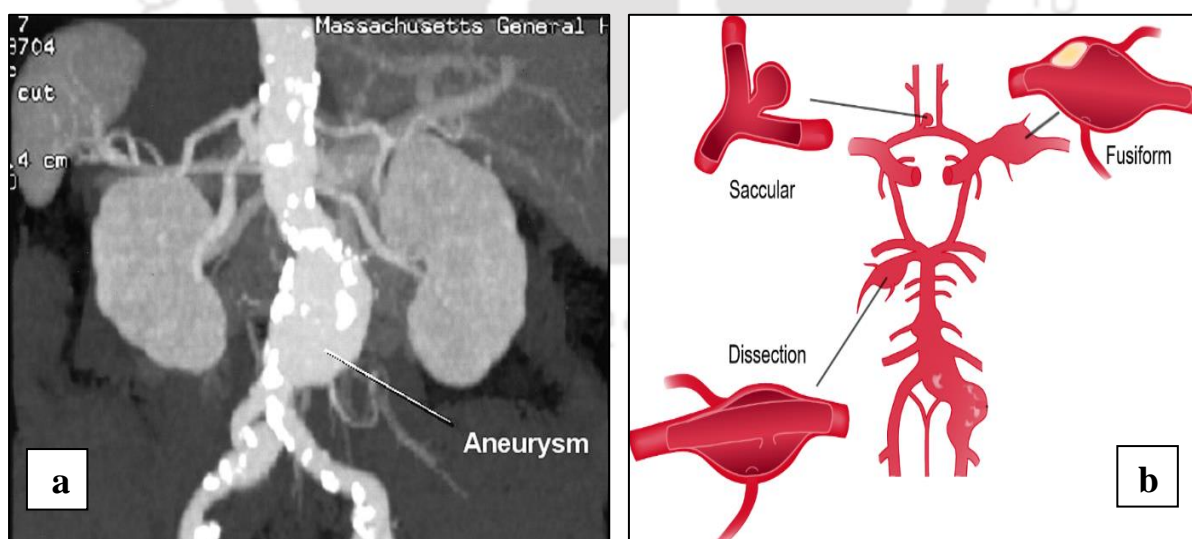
(a) CT image of Abdominal Aortic Aneurysm (below the kidneys);
